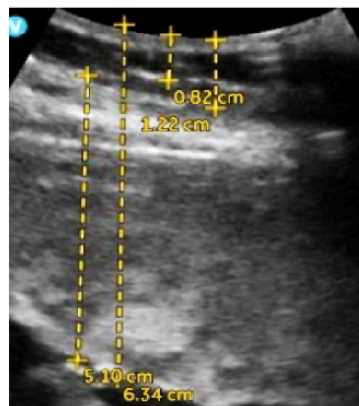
Left: The average DTOF measured during a TD-NIRS scan, with 16 wavelengths (color) and 4 source detector distances, next to ultrasound images demonstrating the placental depth in those cases. Bottom Right: The distribution of placental depths according to the ultrasound scans among the 128 participants.
